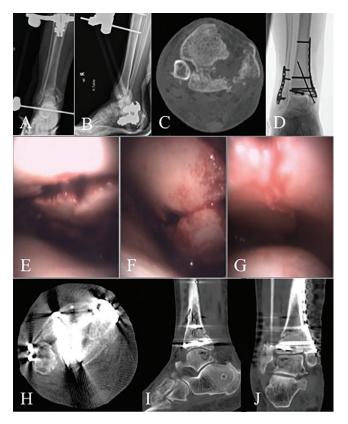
74-year-old female transferred from another facility after spanning external fixation of an intra-articular pilon fracture. Initial x-rays upon presentation demonstrating inadequate reduction in frame, (A) mortise ankle, (B) lateral ankle. (C) Axial computed tomography demonstrating classic pilon articular fragments. Intraoperative fluoroscopy of final reduction and fixation construct (D). Pre clamp placement view with camera looking at articular surface (E), and post clamp placement view using camera (F) to confirm reduction and compression across fracture lines. View at medial shoulder confirming reduction of anterior, medial, and posterior fragments (G). Axial post op CT at joint (H), sagittal post op CT (I) confirming reduction of anterior and posterior articular fragments, and coronal post op CT confirming medial reduction (J).
